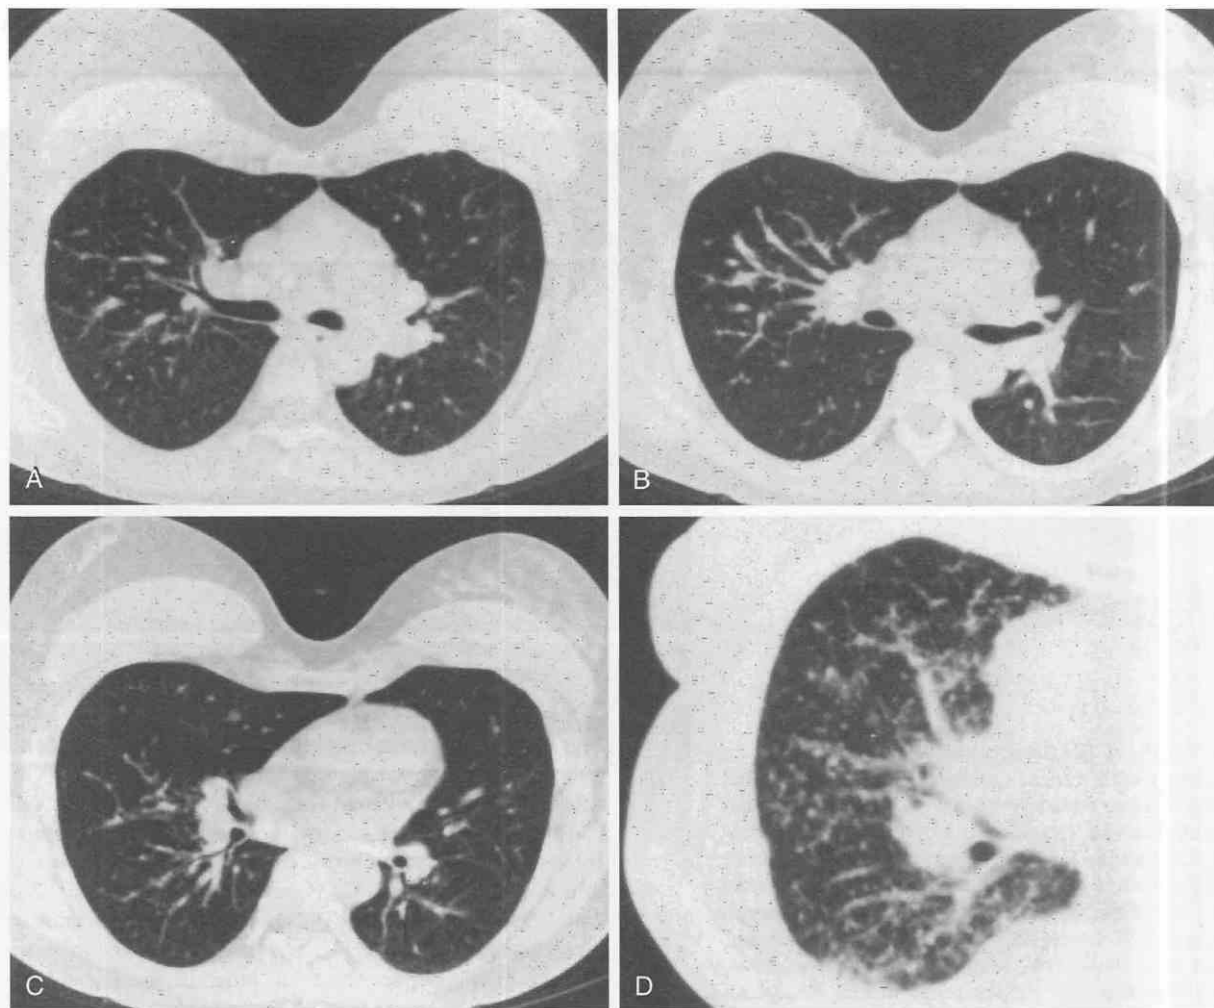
The beaded-septum sign. *A–C*, Prominent nodular thickening of the interlobular septa and the peribronchovascular interstitium due to sarcoidosis results in a CT appearance reminiscent of beads on a string. *D*, The most dramatic examples of the beaded septum sign are the result of lymphangitic spread of tumor, in this case lung cancer. (*D*, From Kuhlman JE: CT of diffuse lung disease. *Appl Radiol* 20:17–21, 1991.)
